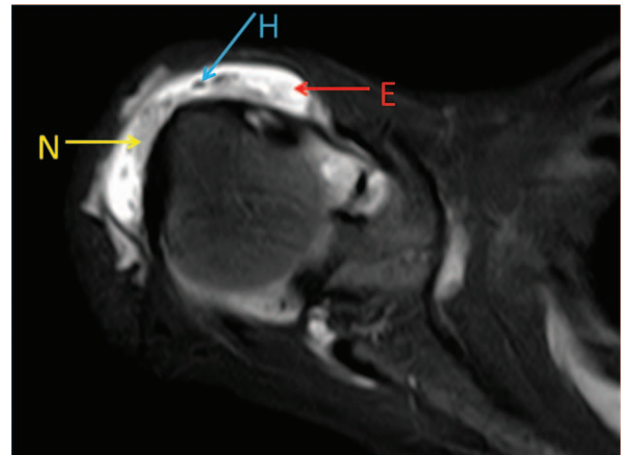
MRI of the right shoulder that shows asynovial nodule (N), joint effusion (E), and hemosiderin deposition (H) within synovial masses.
